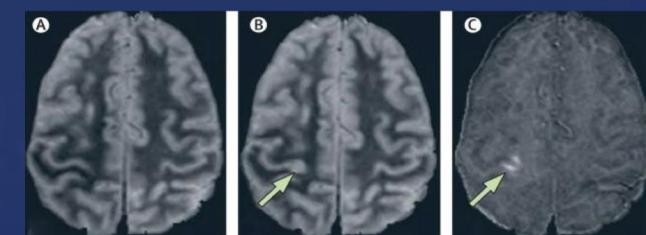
A 44 year-old woman with MS had an MRI of her brain at baseline (A) and after 3 years (B & C). The new lesion is difficult to recognize on the original follow up scan (B), but is clearly visible after subtraction imaging is applied (C).⁵
